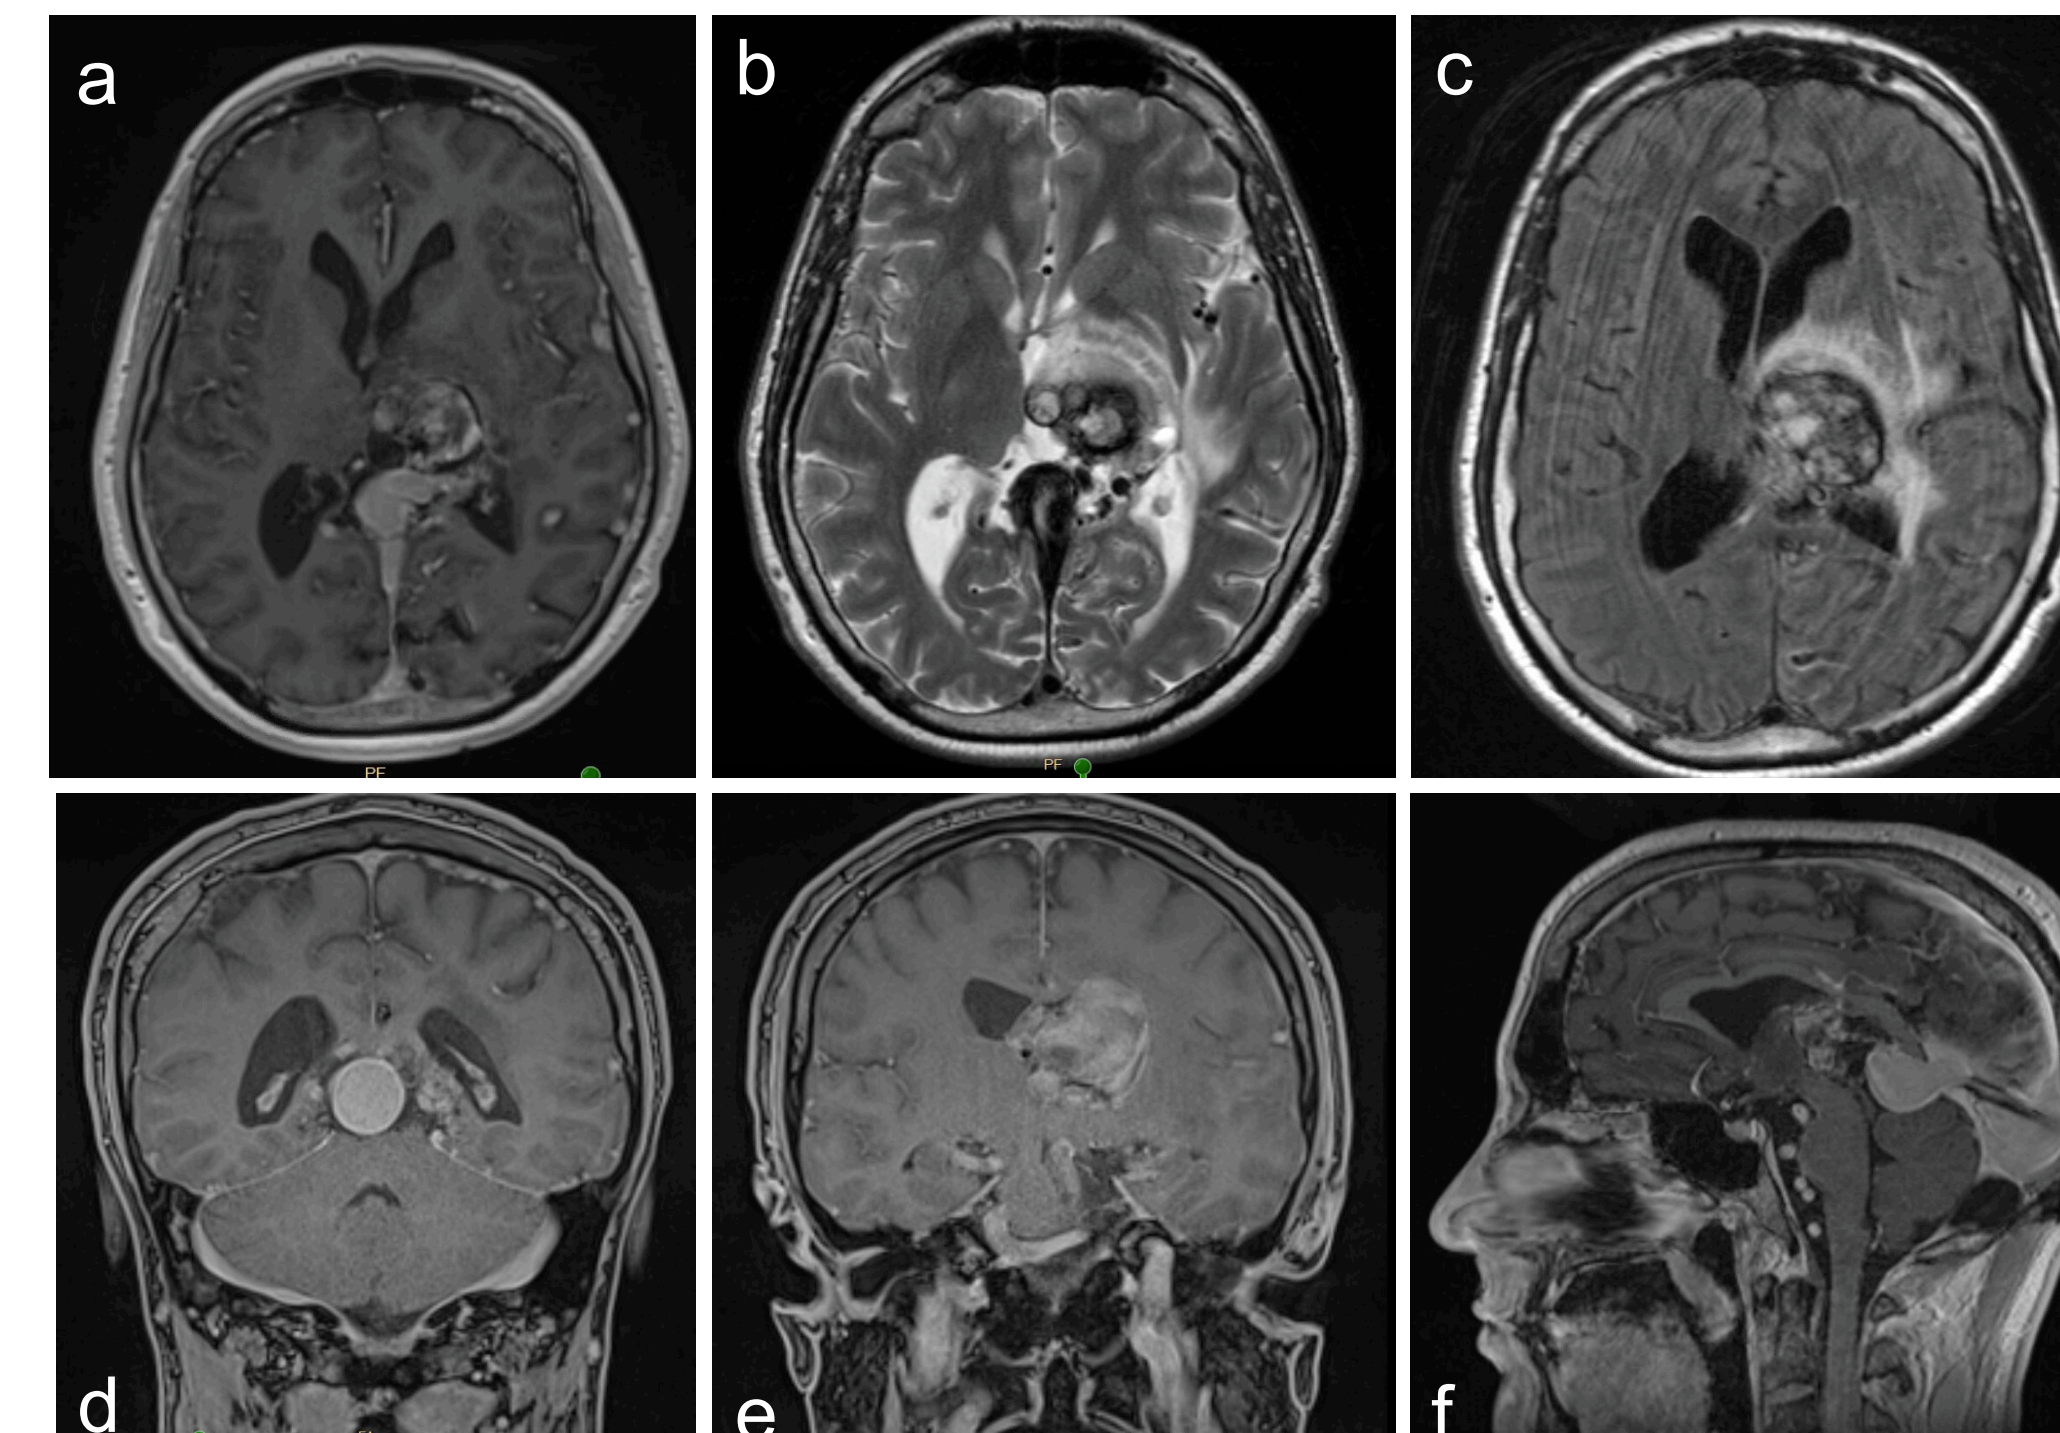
Contrast-enhanced magnetic resonance imaging shows a choroidal-type VoGM with newly embolized arterial feeders, small acute cortical infarcts within the left parietal and occipital lobes, and chronic left thalamic hemorrhage. a. axial T1W, b. axial T2W, c. axial FLAIR, d and e. coronal T1W, f. sagittal T1W.
